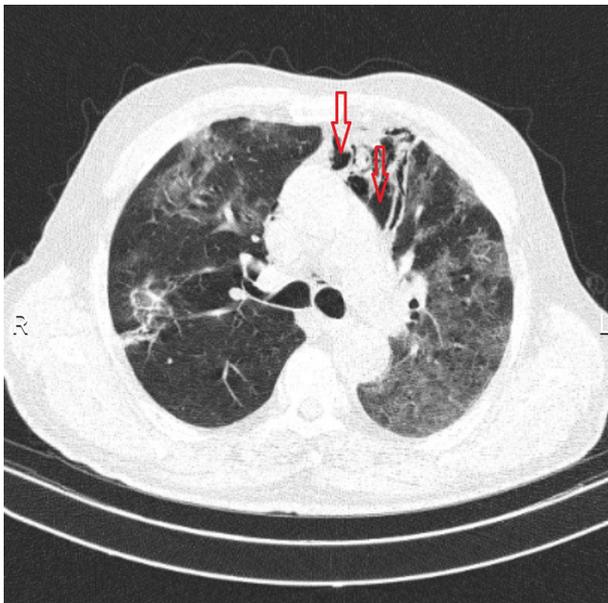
Pneumomediastinum in the chest CT scan and the likelihood of COVID-19.
